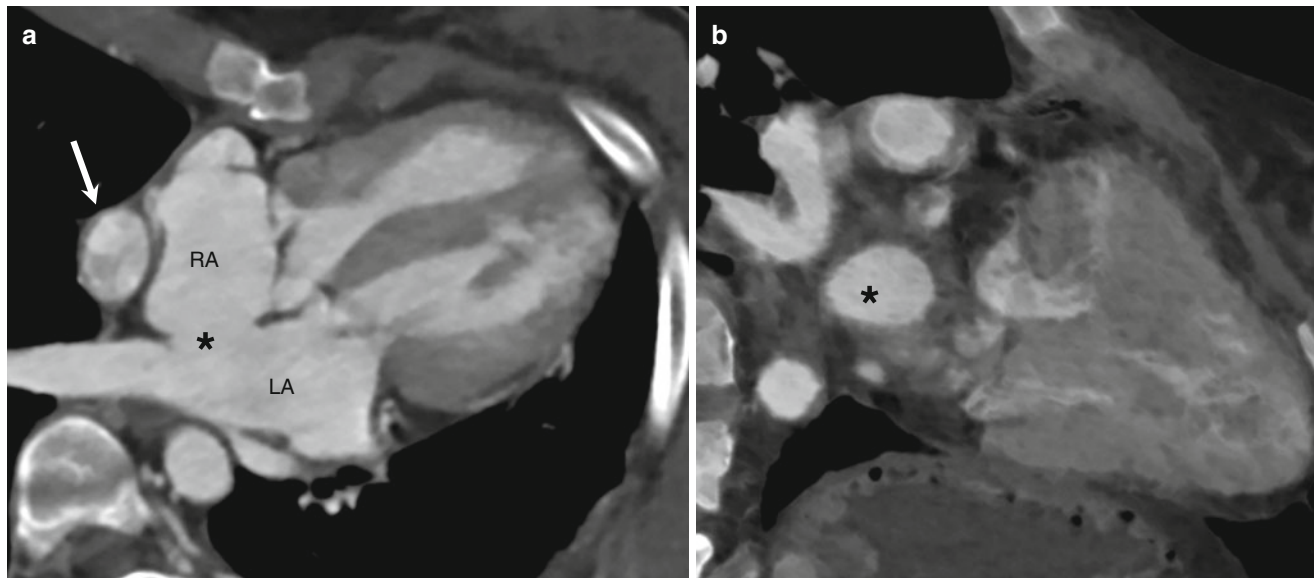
Atrial septal defect. Four-chamber CT image shows a large secundum atrial septal defect (*asterisk*) between the right atrium (RA) and the left atrium (LA) (a). An extracardiac conduit (*arrow*) of Fontan
